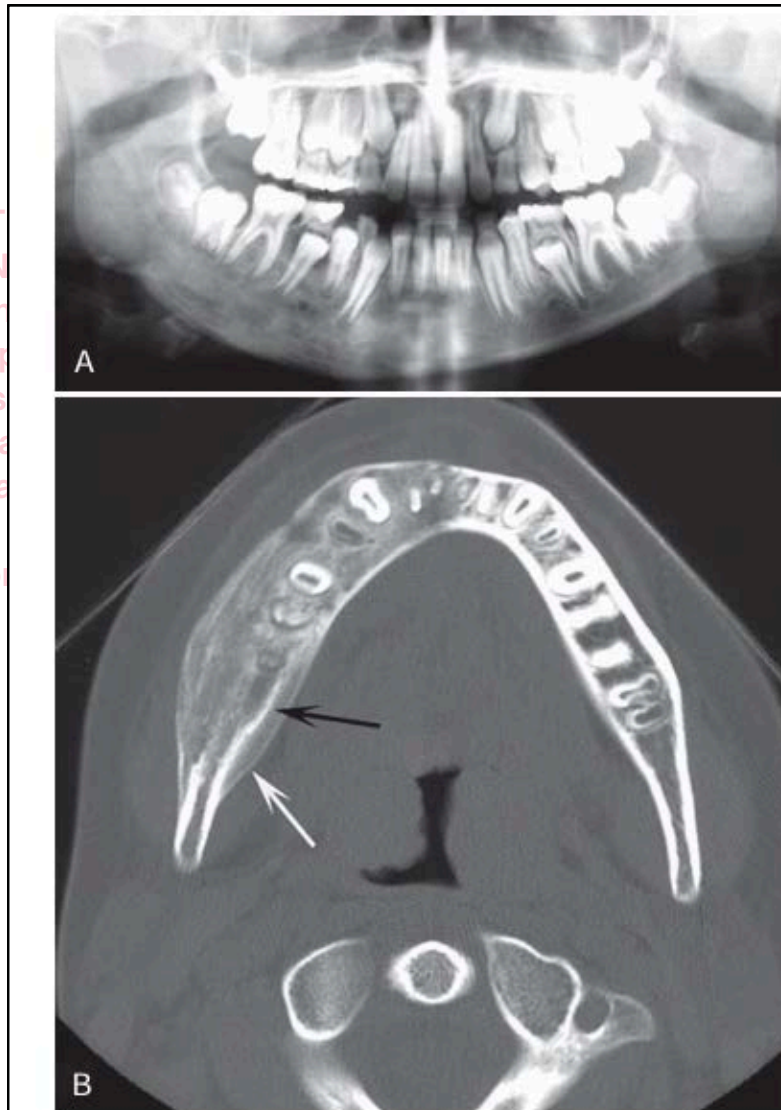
Chronic osteomyelitis. A, This panoramic film demonstrates chronic osteomyelitis of the patient's right mandible; note the increase in density and size of the right mandible compared with the left side. B, An axial CT image using bone window of the mandible of the same case. Note the increase in bone density, width of the mandible, and the new periosteal bone formation (white arrow) and evidence of the original cortex (black arrow).
